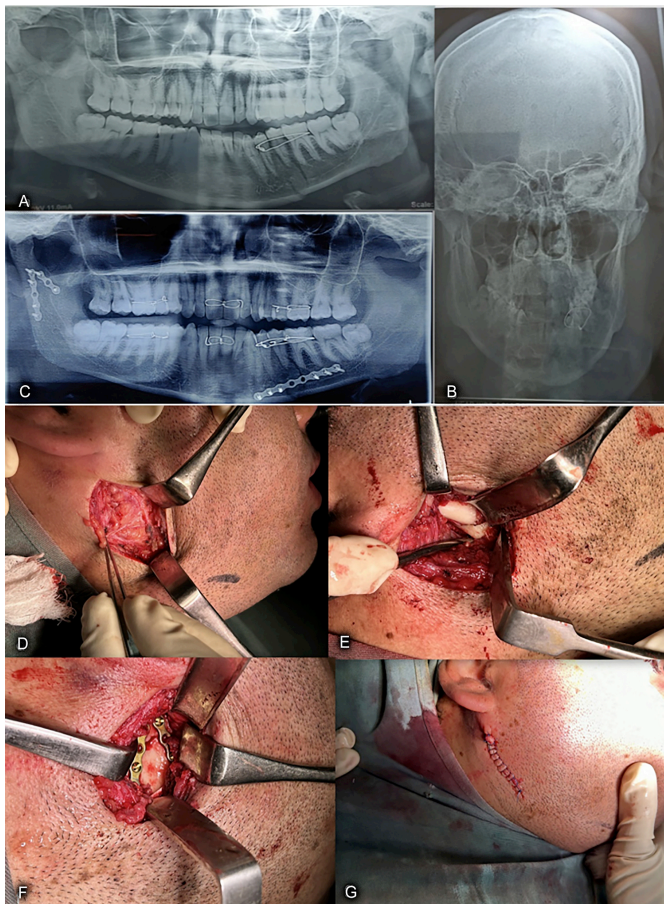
Transparotid approach (A,B) Showing preoperative radiographs (C) Showing postoperative radiograph (D,E,F,G) Showing procedure.
